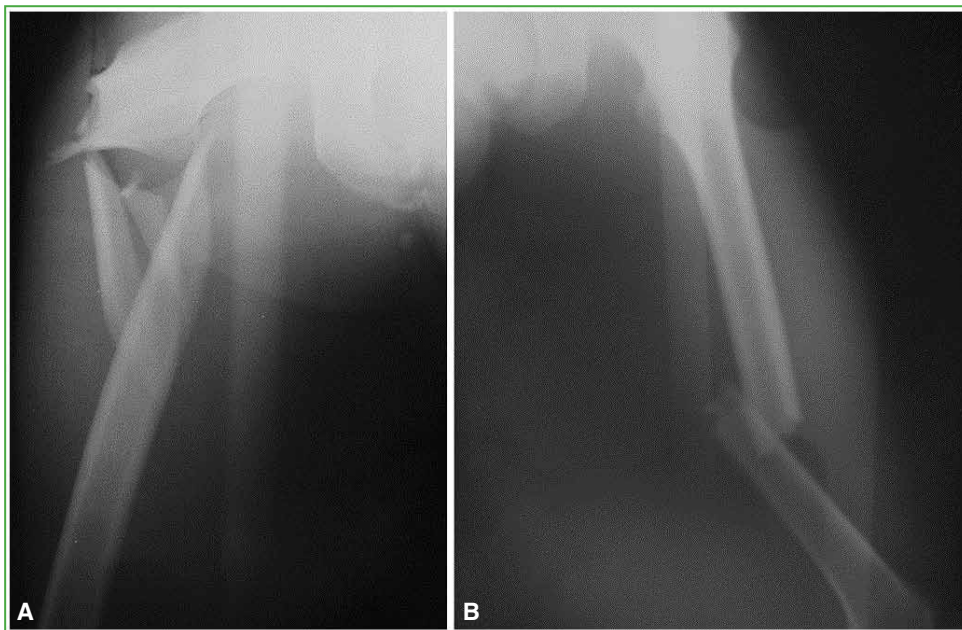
Anteroposterior femur radiographs with evidence of fractures (A. proximal, B. diaphyseal) in patients with floating hip.
